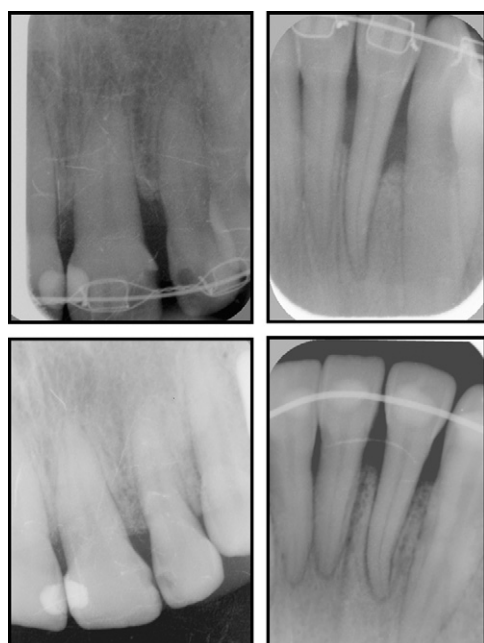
Periapical x-rays: *top row*, elongated teeth in the anterior left side at the start of orthodontic treatment; *bottom row*, significant improvement in the crown and root levels at the end of orthodontic treatment, after intrusion.
